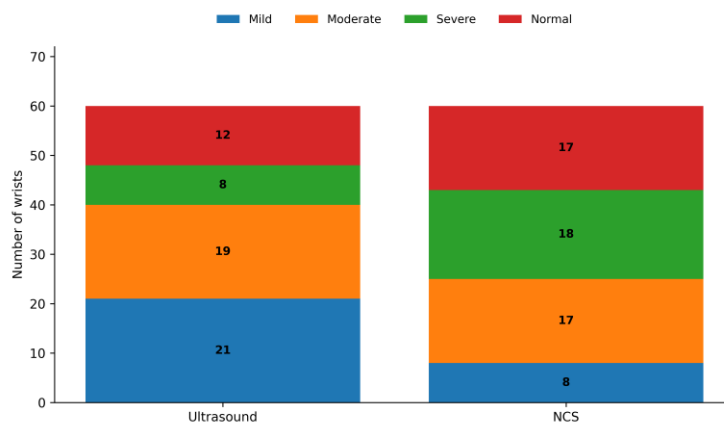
Severity distribution by ultrasound and nerve conduction studies
